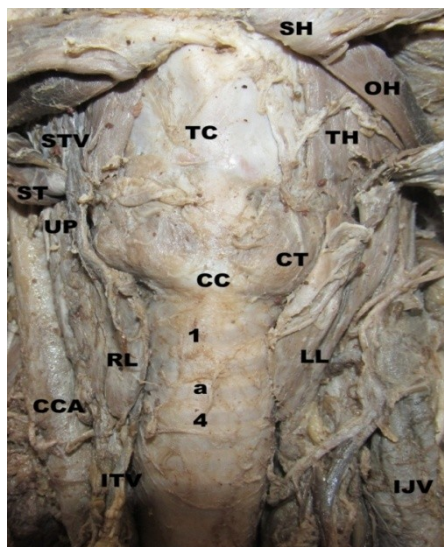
showing the thyroid gland with absent isthmus . 1 – 1st tracheal cartilage , 4 – 4th tracheal cartilage , a – usual site of thyroid isthmus (we can see the 2nd and 3rd tracheal cartilages also because isthmus is not present) , CC – anterior arch of cricoid cartilage , CCA – common carotid artery , CT - cricothyroid muscle , IJV – internal jugular vein , ITV – inferior thyroid vessels , LL – left lobe of thyroid gland , RL - right lobe of thyroid gland , OH – omohyoid muscle(superior belly) , SH – sternohyoid muscle , ST – sternothyroid muscle(reflected upwards) , STV – superior thyroid vessels , TC – thyroid cartilage , TH – thyrohyoid muscle , UP – upper pole of thyroid gland lies deep to sternothyroid muscle (muscle restricts upward enlargement of the gland) .
